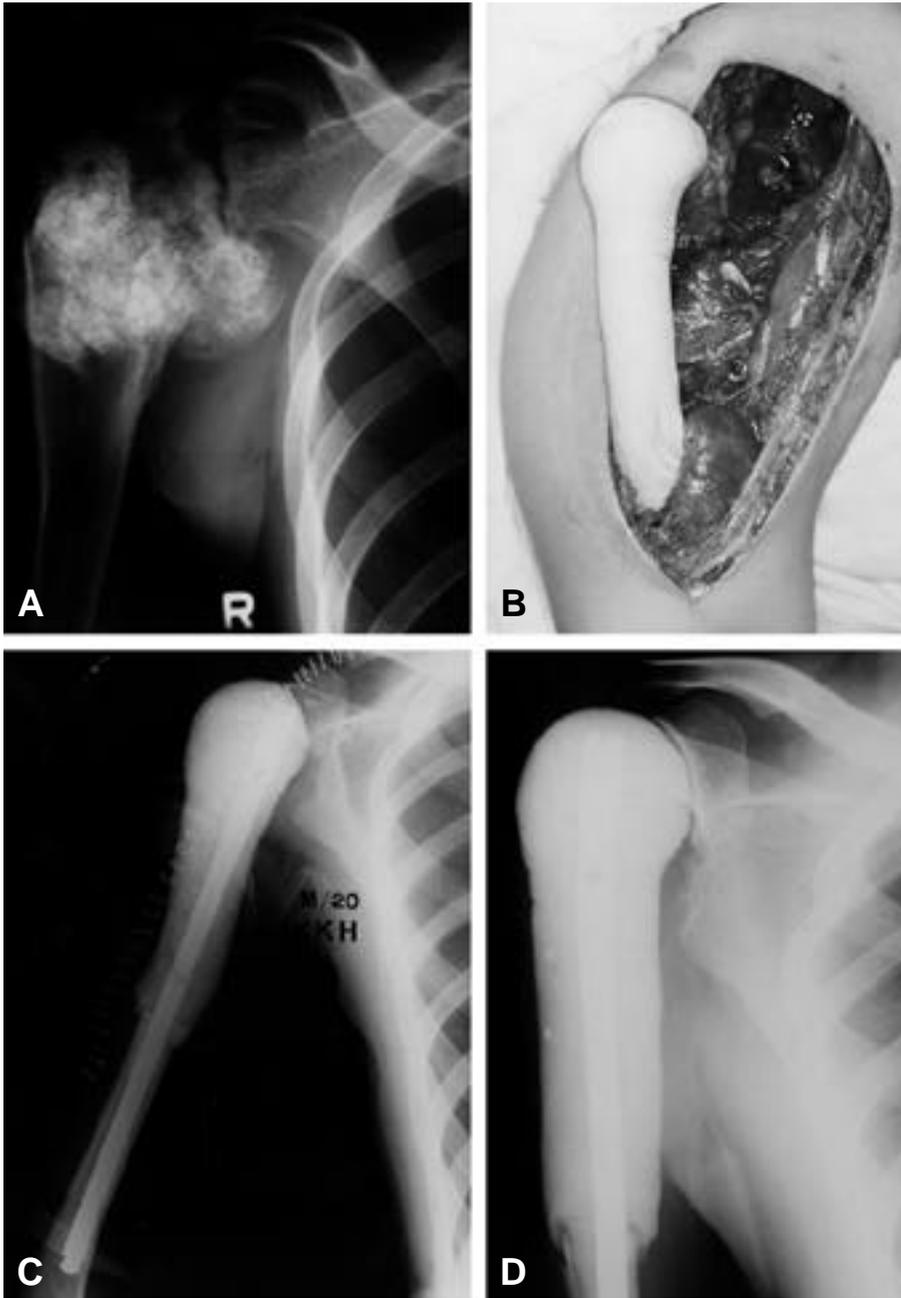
Twenty year-old male patient who had been operated for osteosarcoma of right proximal humerus. A preoperative radiography demonstrated destructive bony lesion with massive osteoblastic reaction in right proximal humerus.
